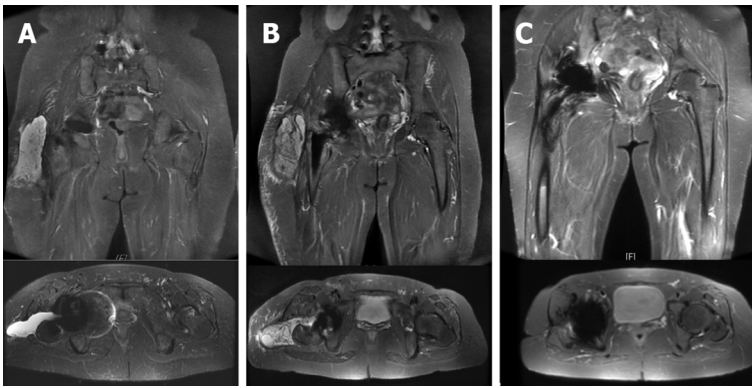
Magnetic resonance imaging series of pre-operative, post-revision surgery, and after Tigecycline local treatment. A: Initial radiographic evaluation: magnetic resonance imaging (MRI) image of right hip showed joint effusion and trochanteric bursitis involving right lateral subcutaneous layer of right artificial hip. The finding corresponds to the diagnosis of pseudotumor; B: MRI image following revision total hip arthroplasty (THA): recurrent periprosthetic pseudotumor over right hip to lateral subcutaneous layer and adjacent subcutaneous inflammation; C: MRI image following revision THA, one month after local tigecycline infusion, showed subsidence of recurrent pseudotumor, periprosthetic soft tissue swelling and effusion.
